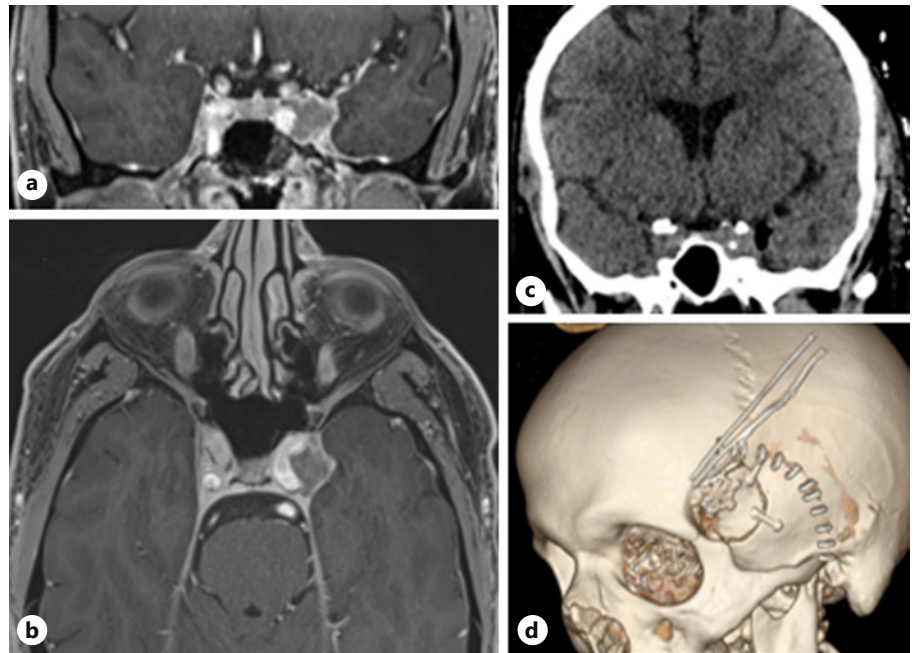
Trancranial extradural CS biopsy. Case of a 55-year-old man with a history of myeloma with long-term remission. The clinical presentation included nerve III palsy and intense retroorbital headache. Diagnoses of myeloma, meningioma, and neurinoma were suspected. Trancranial CS biopsy via a minipterional approach confirmed the diagnosis of myeloma. Preoperative T1-weighted MRI with gadolinium enhancement (a, b). Postoperative CT scan (c) with 3-D bone reconstruction (d).
